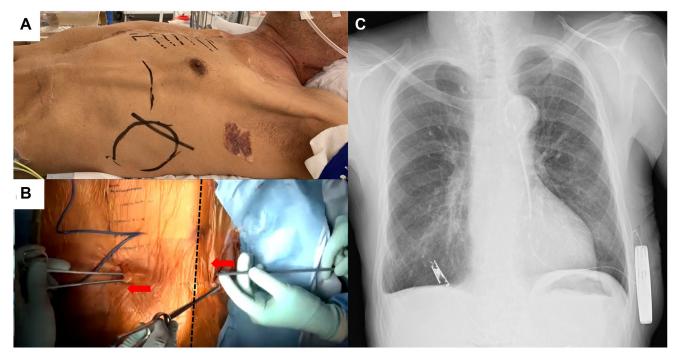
A: Preoperative marking showing the predetermined location of the pulse generator and lead. B: Picture of the insertion of an 11F peel-away sheath under the prosthetic graft (*dotted line*) using straight pean forceps in the direction of the red arrow, which is in the direction from the generator pocket to the mid-incisional line. C: Posteroanterior chest radiograph after implanting the subcutaneous cardioverter-defibrillator with the lead located in the left parasternal position.
